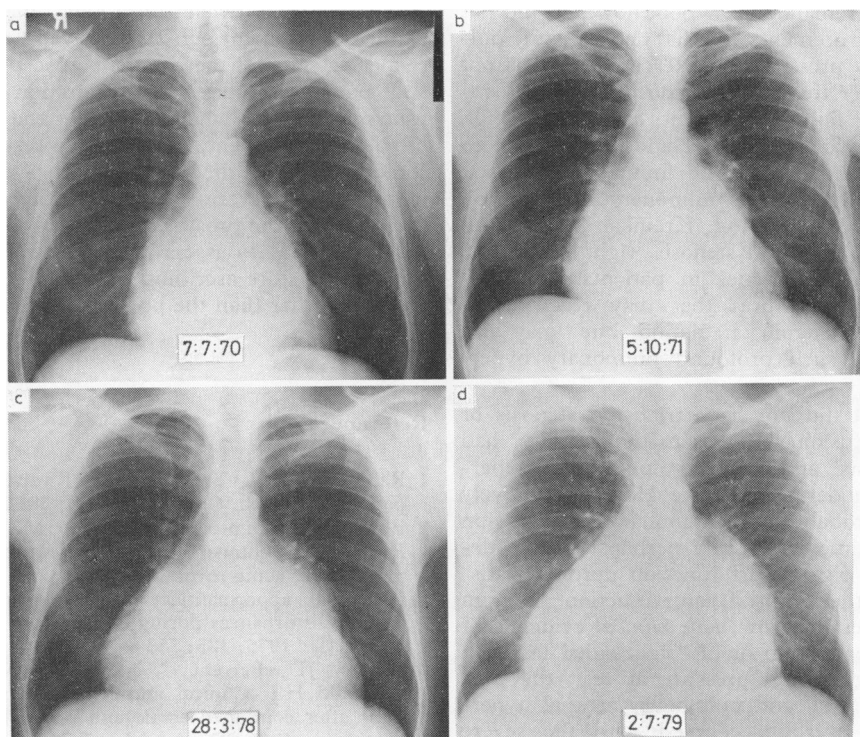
Chest x-ray film in 1970 showing (a) cardiomegaly, considerable enlargement of the left atrium, and probable enlargement of the right atrium; in 1971 (b), 1978 (c), and 1979 (d) progressive cardiomegaly with massive enlargement of the left atrium and considerable enlargement of the right heart is present.
